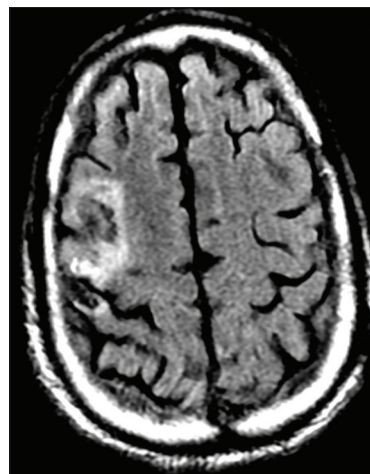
T2 FLAIR Brain MRI showing lesion in the right dorsal premotor cortex
